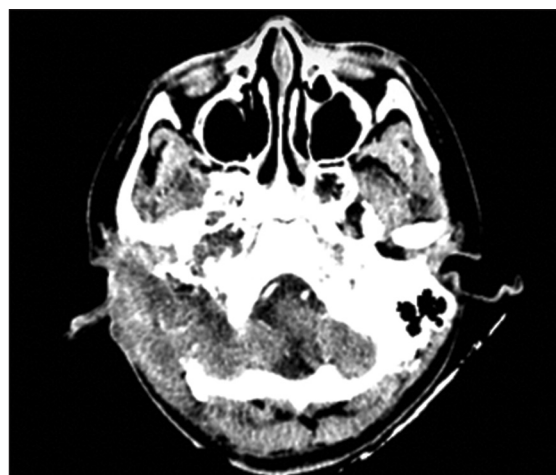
Head computed tomography with contrast in axial view soft-tissue solid mass enhancement, irregular border, in the right jugular fossa, and exophytic.
